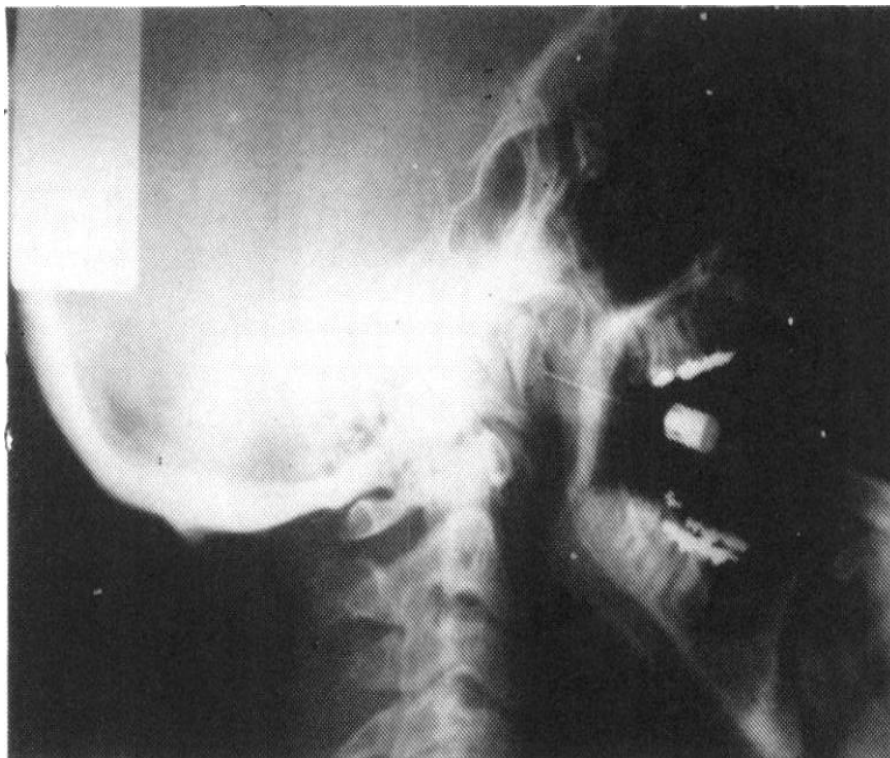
Radiograph showing approximation of the needle to the condylar neck. (31)
